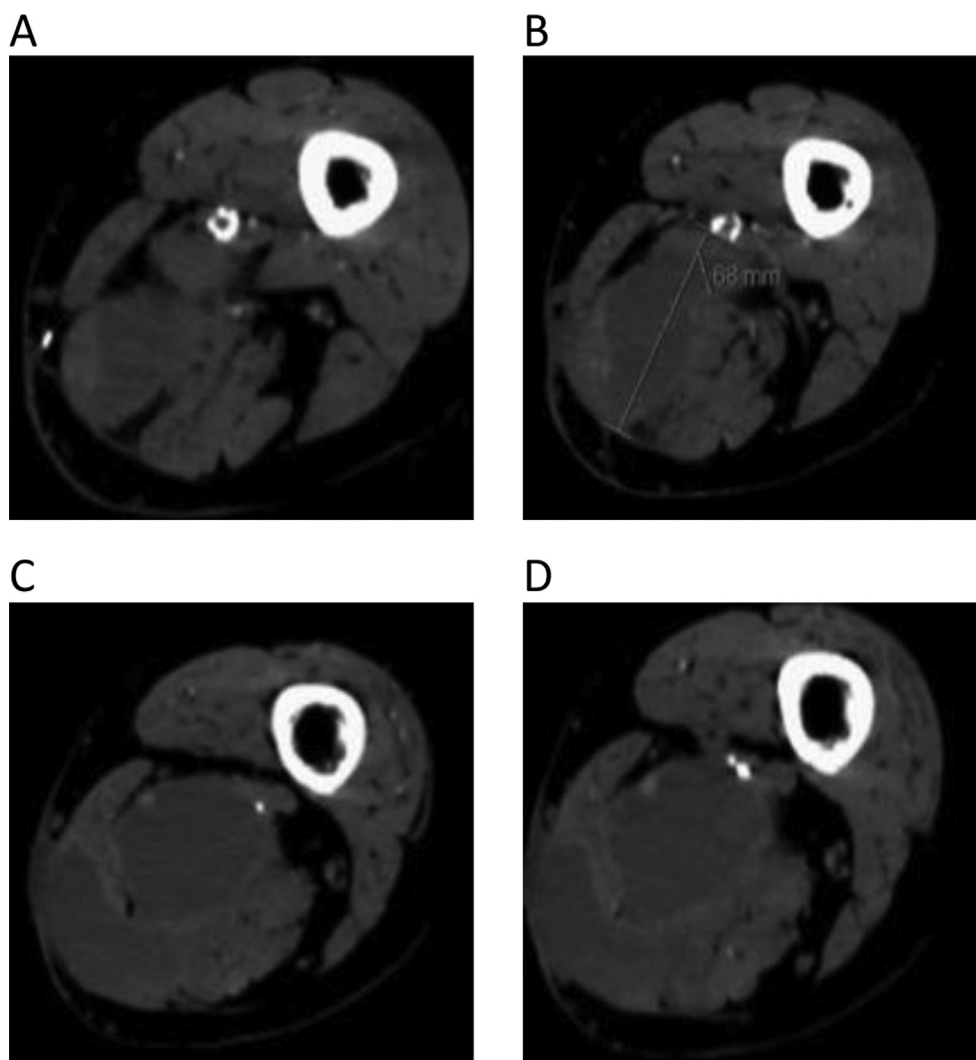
Computed tomography angiography at admission. Autogenous bypass occlusion (A), aneurysmal sac rupture (B) with hematoma formation (C), and skin fistulisation (D).
